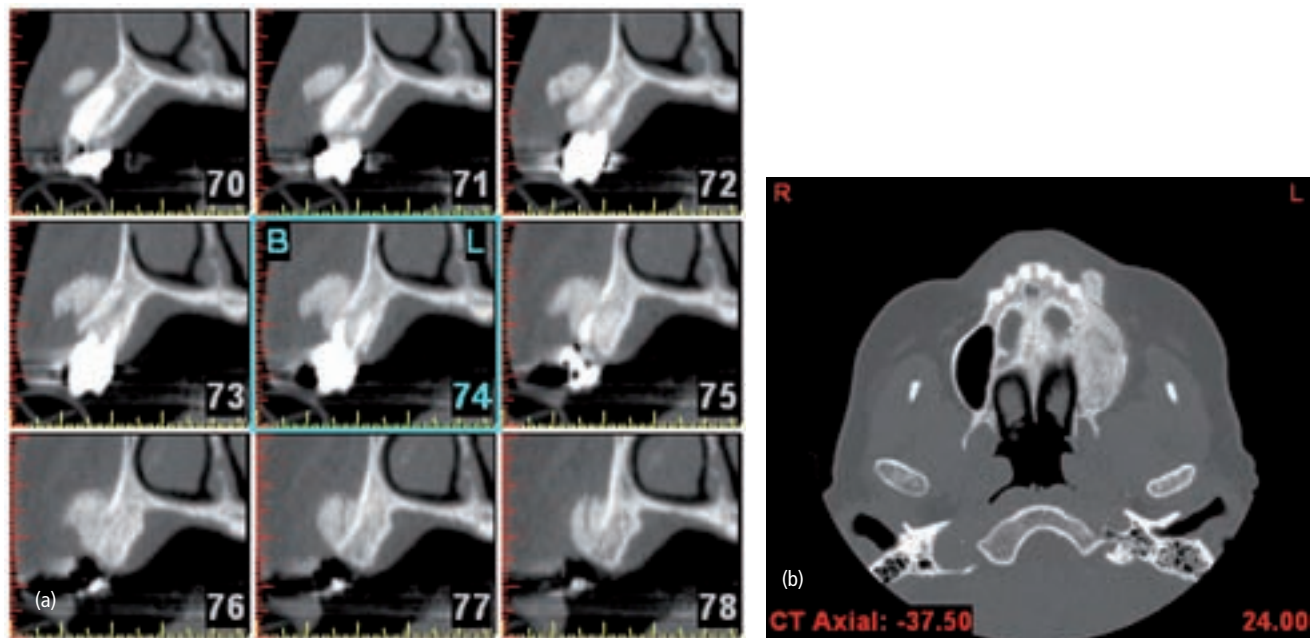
(a) Displaced graft material following intrasinus bleeding (cross-sectional view). (b) Displaced graft material following intrasinus bleeding (axial CT view).
